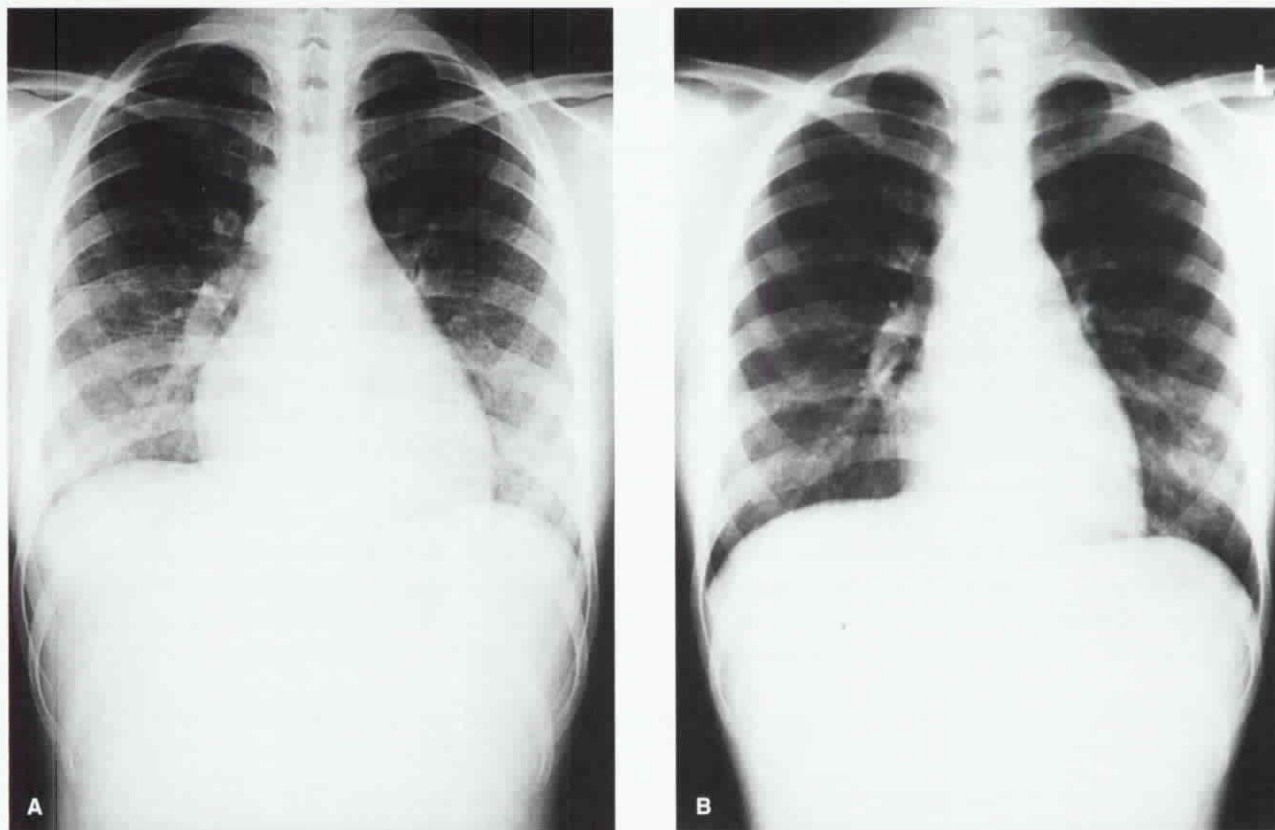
(A) Acute lupus pneumonitis in a 15-year-old female patient with systemic lupus erythematosus. Chest X-ray showed an interstitial pattern with miliary nodules in bilateral lower lung fields. (B) After treatment with two courses of steroid pulse therapy and one course of cyclophosphamide pulse therapy, the chest plain film revealed resolution of the interstitial pattern and miliary nodules in bilateral lung fields.
